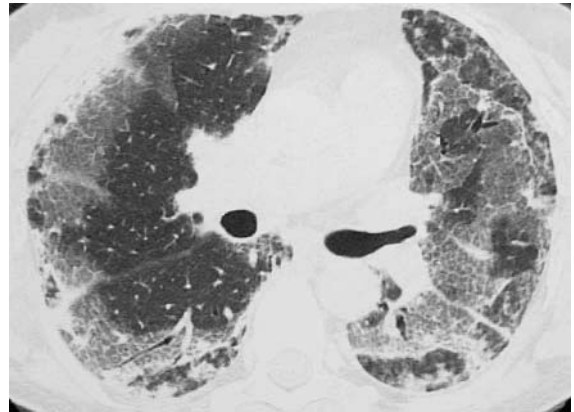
A 46-year-old man with PM. HRCT scan shows bilateral areas of consolidation. The consolidation has a subpleural distribution.
